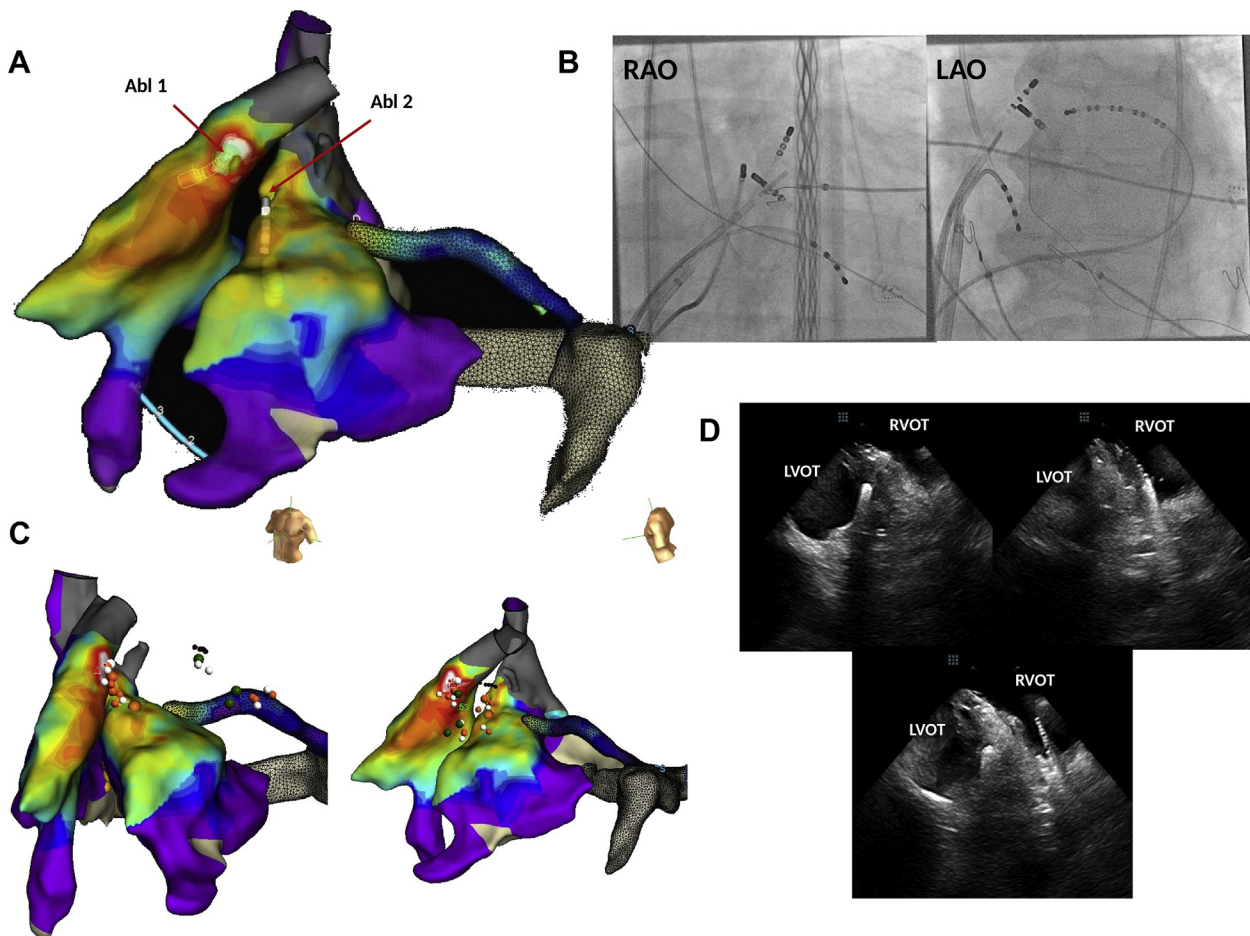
Bipolar ablation. A: Two ablation catheters (Abl1 or active and Abl2 or ground) are positioned in opposite sides of the right ventricular outflow tract (RVOT) and left ventricular outflow tract (LVOT), respectively, with a distance of 20 mm separating them. The active and ground catheters were alternated by switching the connections. B: Position of the catheters on right anterior oblique (RAO) and left anterior oblique (LAO) fluoroscopic views; a decapolar catheter is placed inside the coronary sinus with the distal tip at the level of the great cardiac vein–anterior interventricular vein junction. C: Final lesions delivered from the RVOT and LVOT to achieve premature ventricular contraction elimination. D: Intracardiac echocardiography views of the RVOT/LVOT obtained with the probe positioned at the base of the right ventricle followed by clockwise rotation; the catheter tip position can be discerned by the acoustic shadows; note increased echogenicity of the septum after initial lesions.
